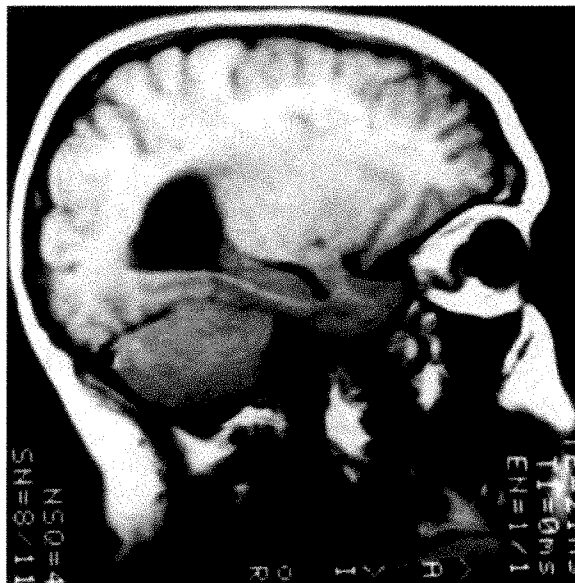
(Imes and Hoyt). Case 1. T_1 -weighted sagittal magnetic resonance image of the left orbit. The optic nerve is elongated and bent downward in the mid-orbit.
